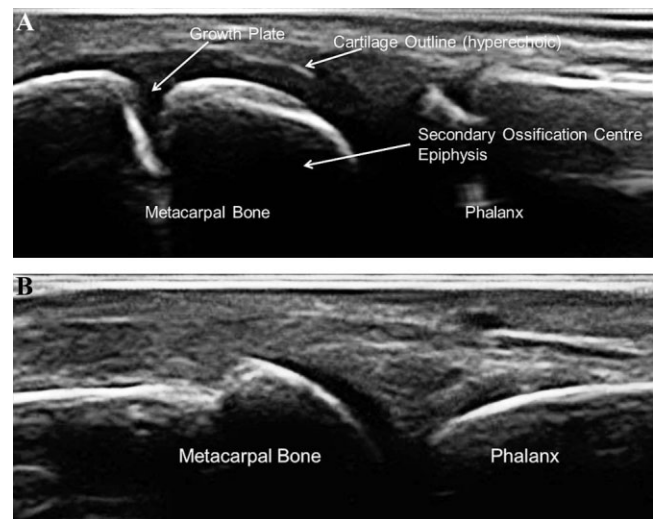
A, Ultrasonographic image of a metacarpophalangeal (MCP) joint in longitudinal view of a 10-year-old. This gray-scale image is showing the hyperechoic outline of the meta-epiphyseal regions of the bones forming the MCP joint with an incompletely ossified epiphysis. Between the diaphysis and the epiphysis, the metaphysis with the growth plate can be seen. Within the hyaline cartilage of the epiphysis, the secondary ossification center is shown. B, Ultrasonographic image of an MCP joint in the longitudinal view of a 15-year-old. This gray-scale image is showing the outline of the meta-epiphyseal regions of the bones forming the MCP joint with a completely ossified epiphysis. Only the articular portion of the hyaline cartilage remains.
